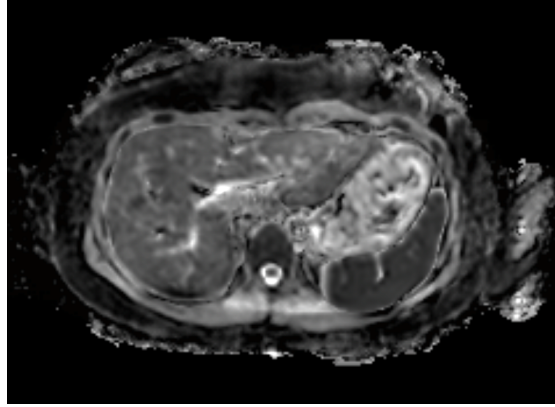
ADC Map of the upper abdomen acquired through DWI in the axial plane.
